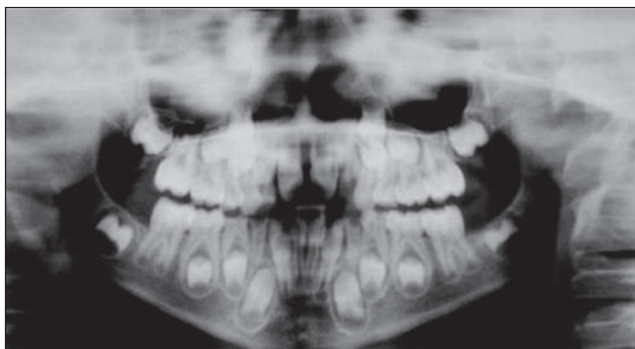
Panoramic radiograph taken at the age of 7 years. The number of teeth is correct.
